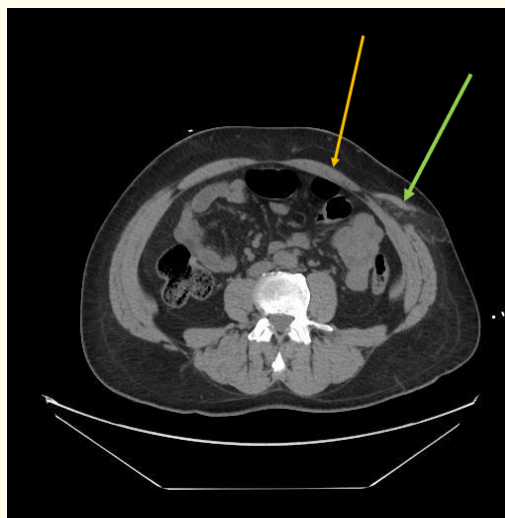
CT scan axial view showing the external oblique rupture due to previous penetrating trauma from a stab wound (green arrow) lateral to the left rectus abdominis (orange arrow).
